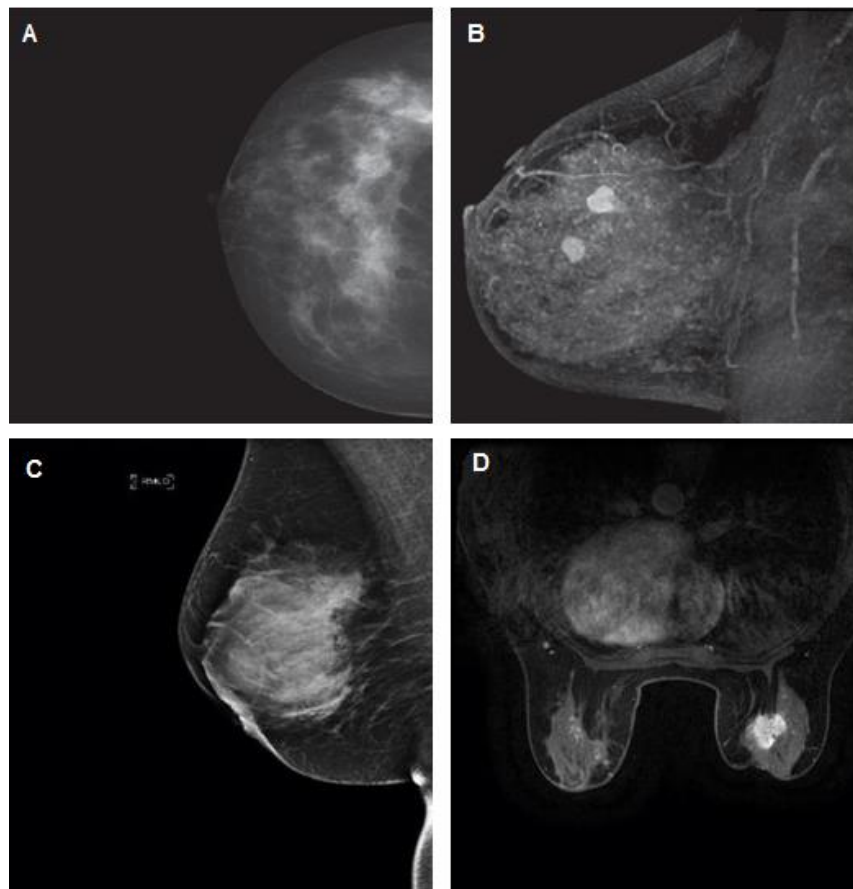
Comparison of X-ray Mammography vs. MRI (A) Negative X-ray mammogram of 43-year old woman. (B) contrast enhanced MRI of the same breast identifying multifocal carcinoma (C) sagittal X-ray mammogram revealing abnormal tissue density. (D) contrast enhanced MRI of same patient identifying (Morrow *et al*, 2011; Davies, 2012)
